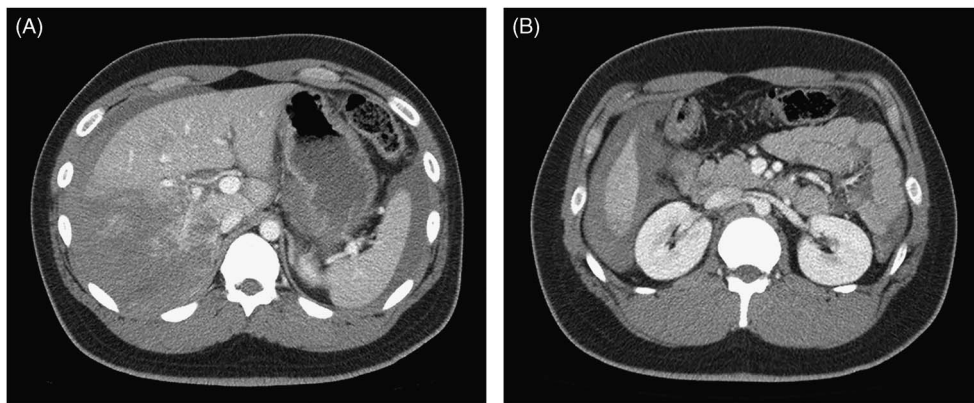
and 1B. Contrast-enhanced abdomen CT scan post-trauma showed lacerations in the right hepatic lobe with moderate amount hemoperitoneum.
